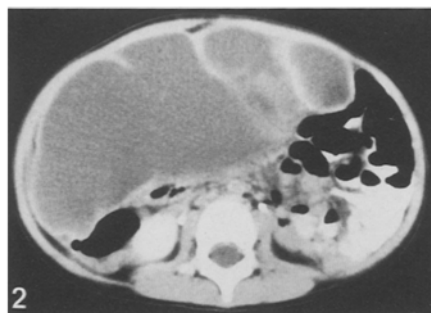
CT section through mid-abdomen demonstrates a large intraperitoneal fluid collection, which appears to displace bowel centrally. The fluid did not layer dependently in the pelvic cul-du-sac, and did not disperse around liver and spleen
